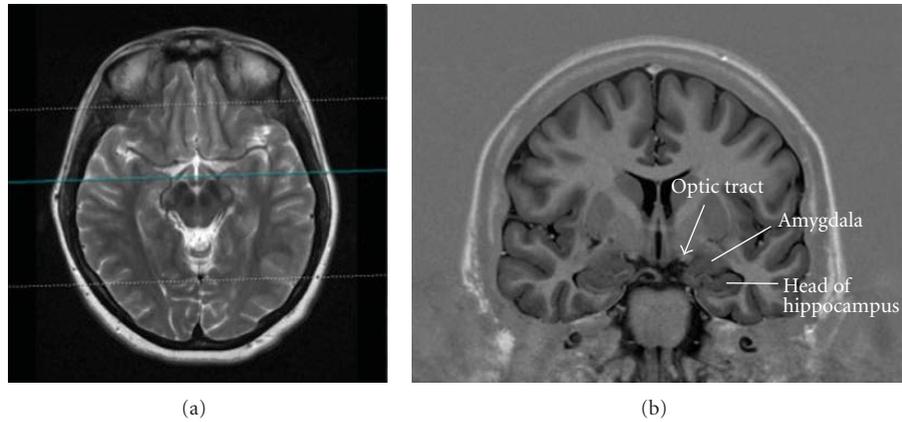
MRI coronal inversion recovery image (right) at the level of optic tract ((a), blue line) depicting the anatomical relationship of the amygdala to the optic tract (b).
